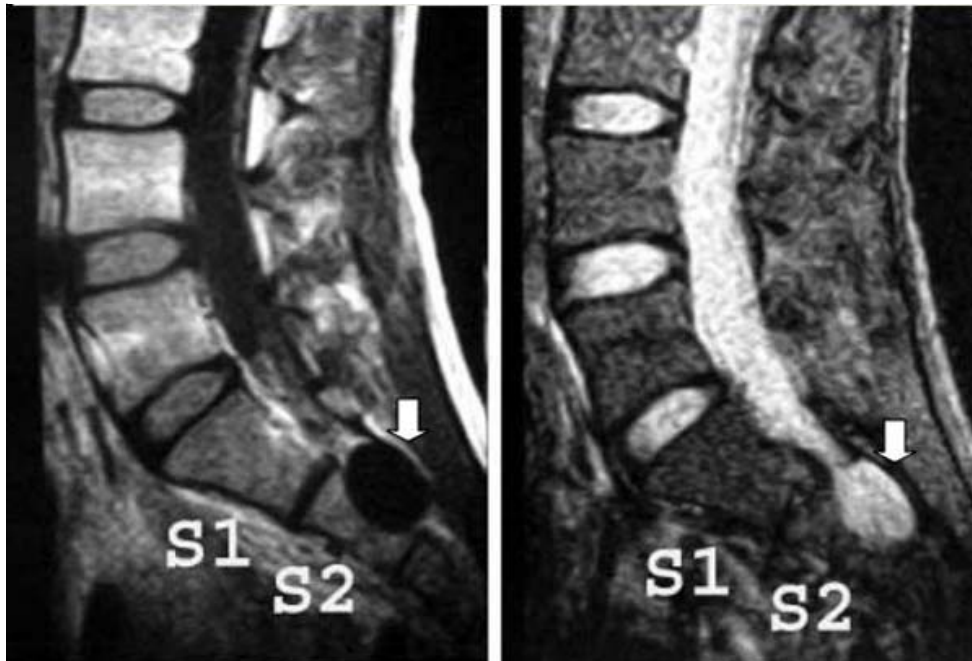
MRI of lumbosacral spine-The sagittal (T1 weighted-left, T2 weighted-right) views show the cystic lesion (arrows) in spinal canal and scalloping of body of S2
